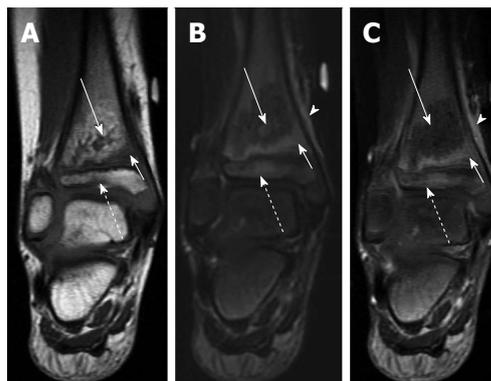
Transphyseal methicillin-resistant *Staphylococcus aureus* osteomyelitis with intraosseous abscess. A: Coronal T1-weighted image of the right ankle shows an area of T1 hyperintensity in the distal tibial metaphysis with central T1 hypointensity (solid long arrow) indicative of abscess formation. T1 hypointensity is seen surrounding this area in metaphysis (solid short arrow) and in the epiphysis (dashed arrow) indicative of transphyseal spread; B: Coronal T2-weighted image with fat suppression shows an area of T2 hypointensity with central T2 hyperintensity (solid long arrow) corresponding to the areas of abnormal T1 signal in A. T2 hyperintensity in the distal metaphysis (solid short arrow) and epiphysis (dashed arrow) are consistent with edema. T2 hyperintensity in periosteum and adjacent soft tissues indicating inflammation (arrowhead); C: Coronal T1-weighted image post contrast shows a lack of enhancement in the central distal metaphysis consistent with necrosis and abscess formation (solid long arrow). Enhancement is seen peripherally in the distal metaphysis and epiphysis (solid short arrow and dashed arrow). Enhancement in periosteum and adjacent soft tissues indicating inflammation (arrowhead).
